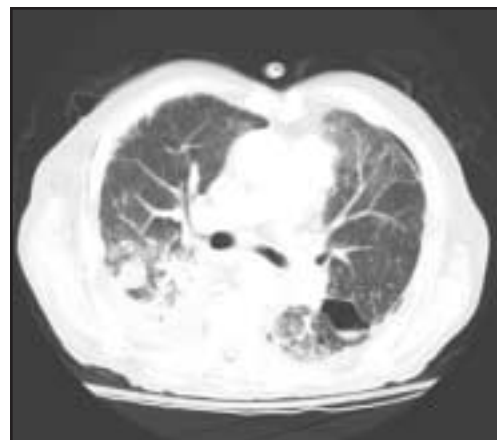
CT scan demonstrates a small left pneumothorax that extends into the most superior portion of the major fissure, which also contains a small amount of fluid. Note the pulmonary laceration in the right lung in this trauma patient.
